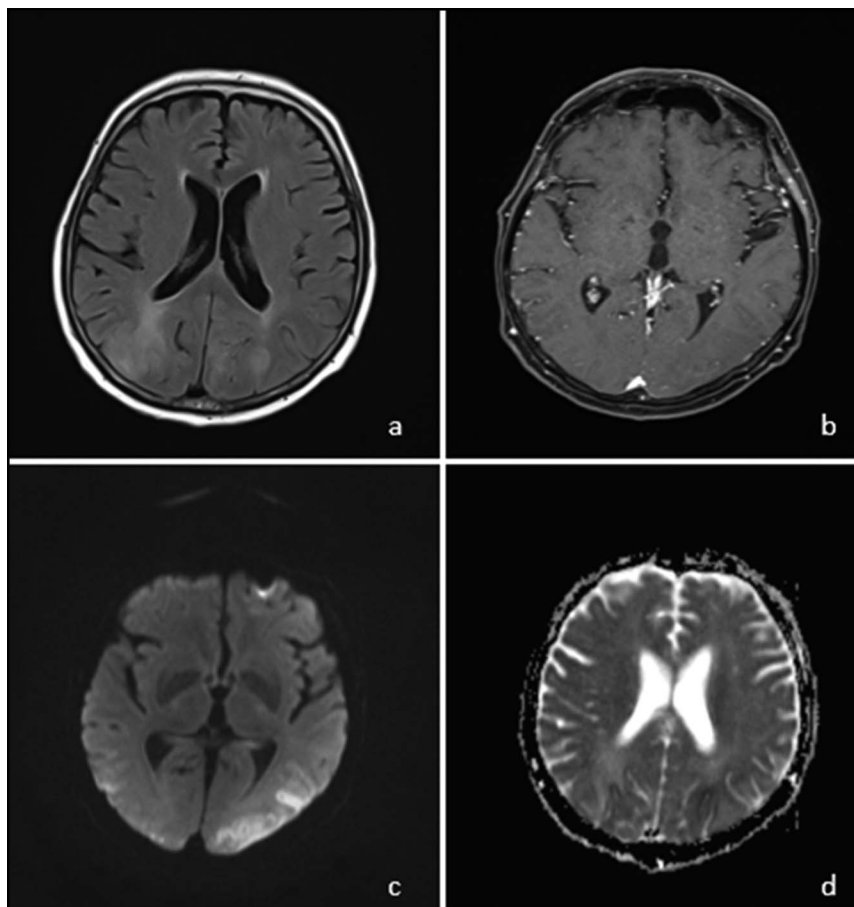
Magnetic resonance imaging alteration of the signal associated with diffusion restriction in the occipital lobe, suggestive of cerebral edema in (A) fluid-attenuated inversion recovery sequence, (B) after contrast injection, (C) diffusion weighted imaging sequence, (D) apparent diffusion coefficient sequence.
